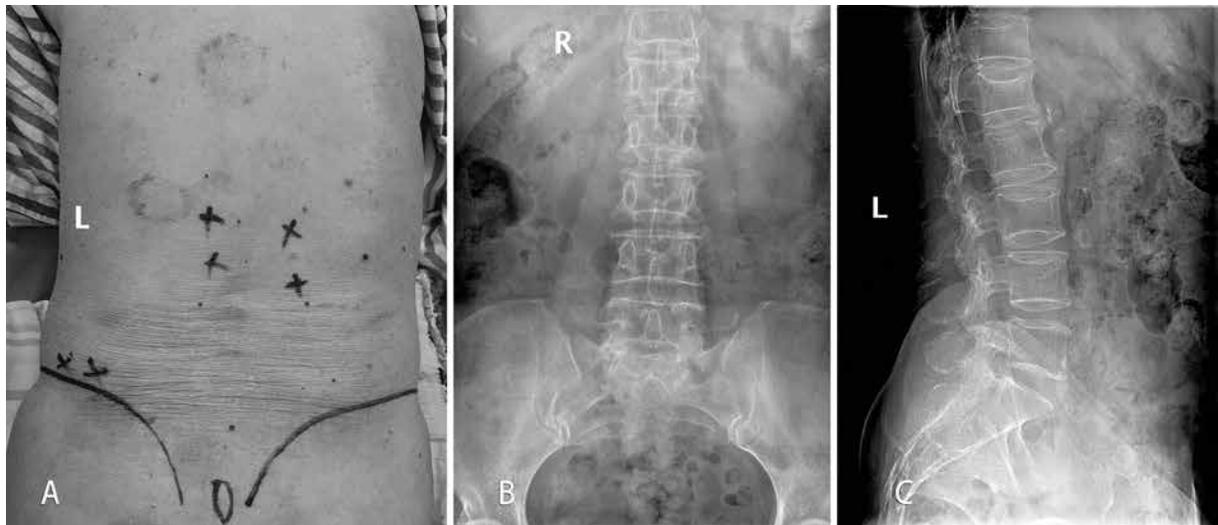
Patient One is a 66-year-old with an L1 osteoporotic vertebral compression fracture (OVCF) accompanied by superior cluneal neuralgia (SCN). A: The patient is placed in a prone position. The 2 longest symmetrical black lines represent the surface projections of the iliac crest and the posterior superior iliac spine. The circle in the middle represents the surface projection of the uppermost edge of the sacral median crest. The black crosses indicate the patient's back's tender points, with the 2 crosses above the left iliac crest representing the trigger points aggravated by SCN. The 4 crosses beside the central spine represent facet joint tender points, which are related to the vertebral fracture. B and C are images of the preoperative lumbar vertebral anteroposterior and lateral x-ray examinations of the patient, showing a wedge-shaped deformity of the L1 vertebra, indicating an L1 vertebral compression fracture.
